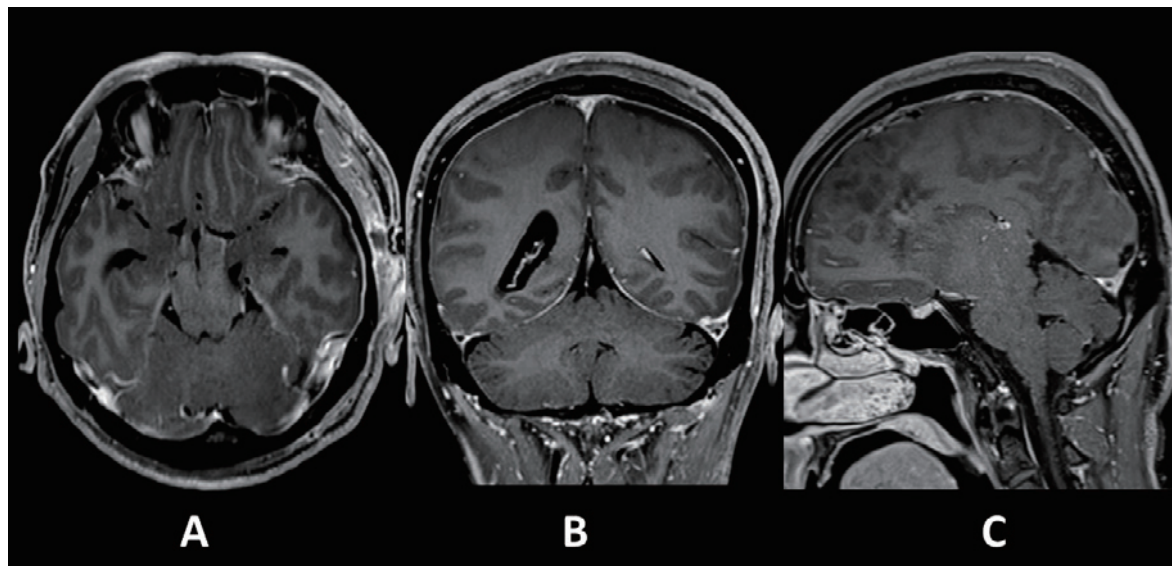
Gd-enhanced T1-weighted MR imaging performed on POD 5 showing strong meningeal enhancement without marked pituitary enlargement. A, axial image; B, coronal image; C, sagittal image.
